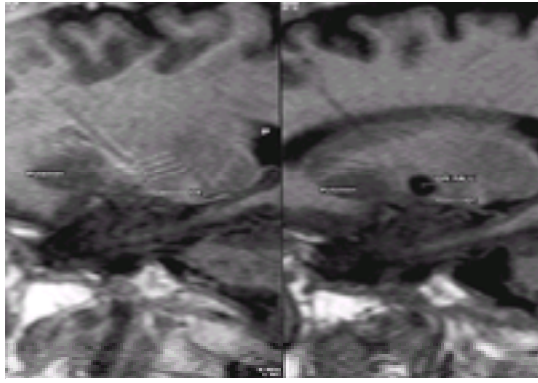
Parasagittal MRI of the brain 6 h after placement of deep brain stimulation in the internal segment of globus pallidus (GPI). Technique is the same as in [Fig. 4](#). The four contacts can be identified (arrows) above the optic tract (OT) in GPI. On the opposite side is a pallidotomy more than 6 months postoperatively.
